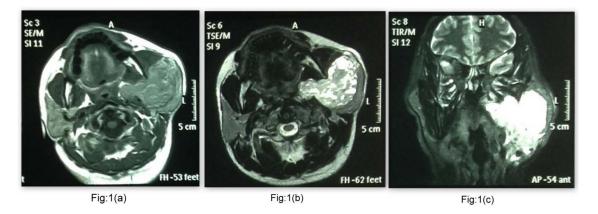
MRI image showing hypointense axial T1-weighted lesion (a) hyperintense axial T2weighted lesion (b) hyperintense coronal T2-image (c)
